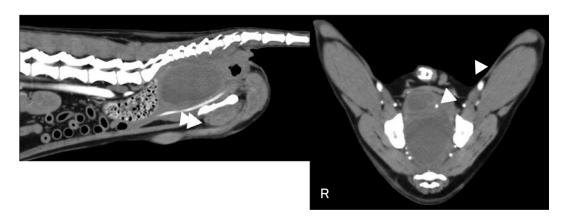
Contrast enhanced computed tomography showed a large, tumorous, cystic prostatic lesion was noted. The lesion occupied the pelvic cavity and ran caudally along the right side of the rectum to the perineum (Arrowhead: catheter). Left: sagittal plane, Right: transverse plane.
